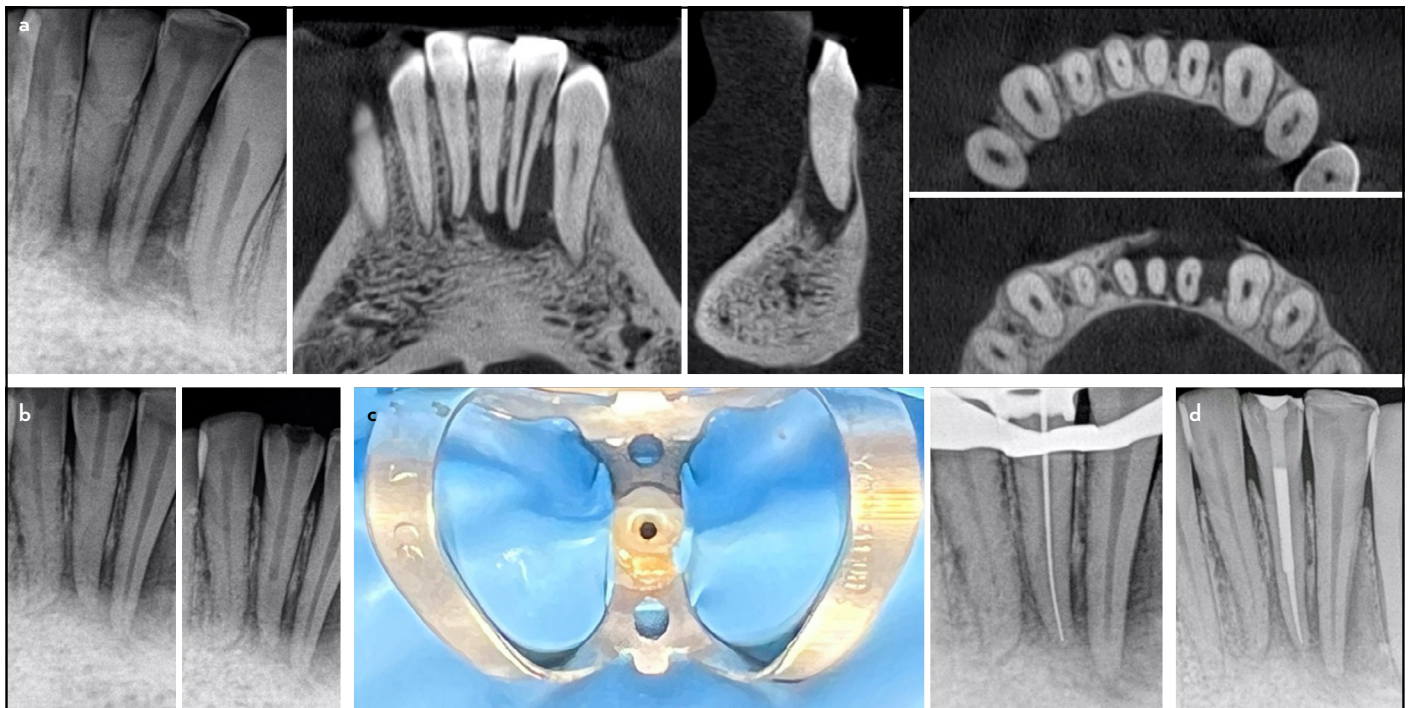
Case 9. (a) Pre-operative radiograph and CBCT scan showing the degree of root canal obliteration and periapical lesion. (b) Intraoperative radiographs monitoring drilling depth and the trajectory of the bur. (c) Photograph showing the minimally invasive approach, and radiograph confirming root canal access. (d) Postoperative radiograph. A clinical view with the guide placement is not available in this case
